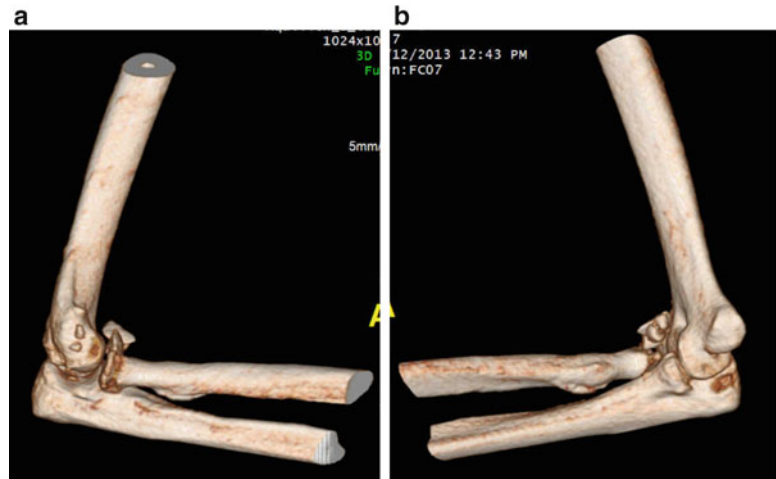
3-Dimensional reconstruction CT scan of a right elbow with a terrible triad injury, as viewed (a) laterally and (b) medially
